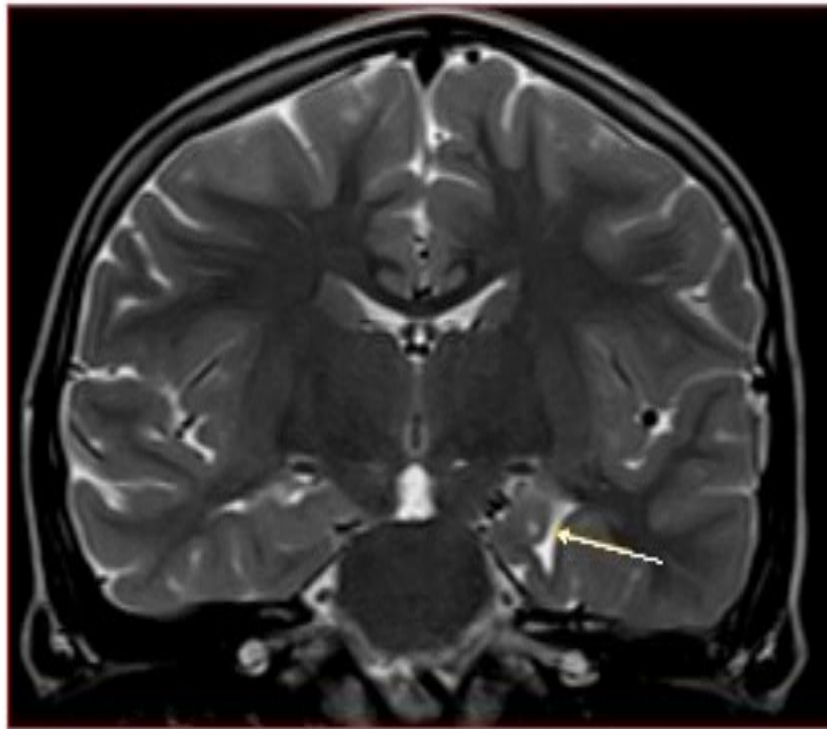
Coronal MRI T2 Image of a four-year-old presenting with focal seizures; arrow shows abnormal shaped left hippocampal head
